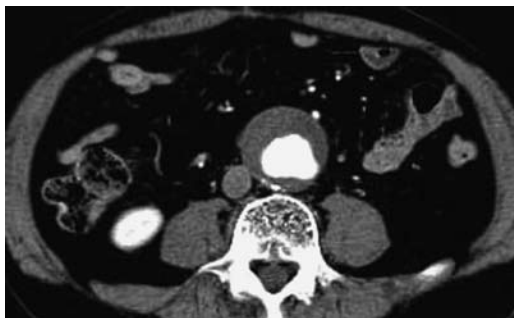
Abdominal CT showing a dilated segment of the infrarenal abdominal aorta measuring 52mm.
